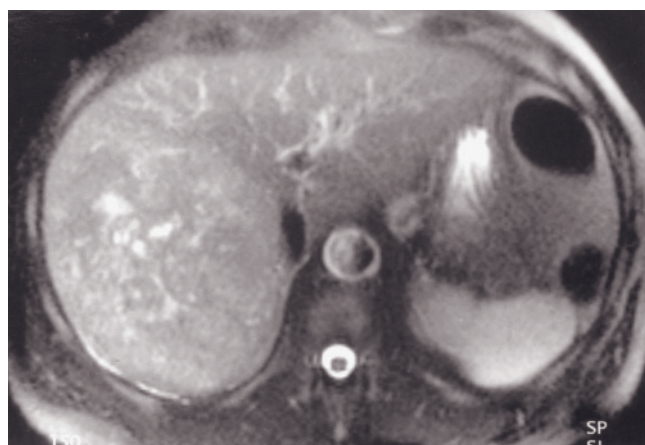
Multifocal HCC-spiral and multidetector CT and MR comparison. Spiral CT (a), fat-suppressed T2-weighted ETSE (b), and immediate postgadolinium SGE (c) images. The spiral CT image demonstrates a solitary HCC in a patient with 8 HCCs shown on MRI tumors. No tumors are evident on CT at this tomographic level (a). The T2-weighted image (b) demonstrates two 1.8-cm HCCs at this level that have high-signal-intensity peripheral rims and are isointense centrally (arrows, b). On immediate postgadolinium image (c), these tumors enhance in a predominantly ring fashion (arrows, c).
